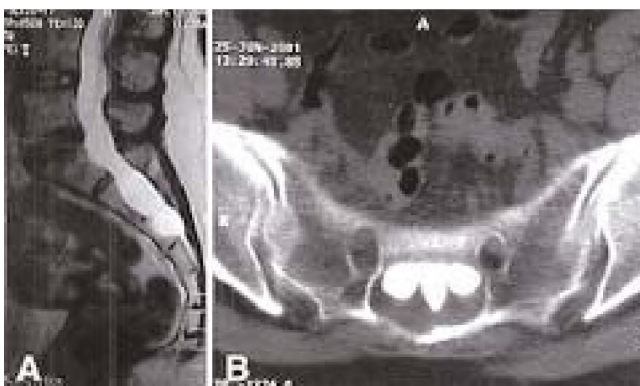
Preoperative imaging studies. A: Sagittal T₂-weighted MR image revealing a high signal intensity cystic lesion in the sacral spinal canal. B: Axial CT myelogram of the sacrum demonstrating a Tarlov cyst.
